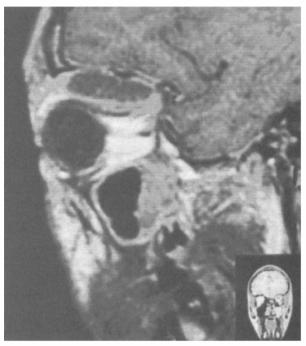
Case 1. A sagittal MRI image through the left orbit showing a superior orbital collection.
